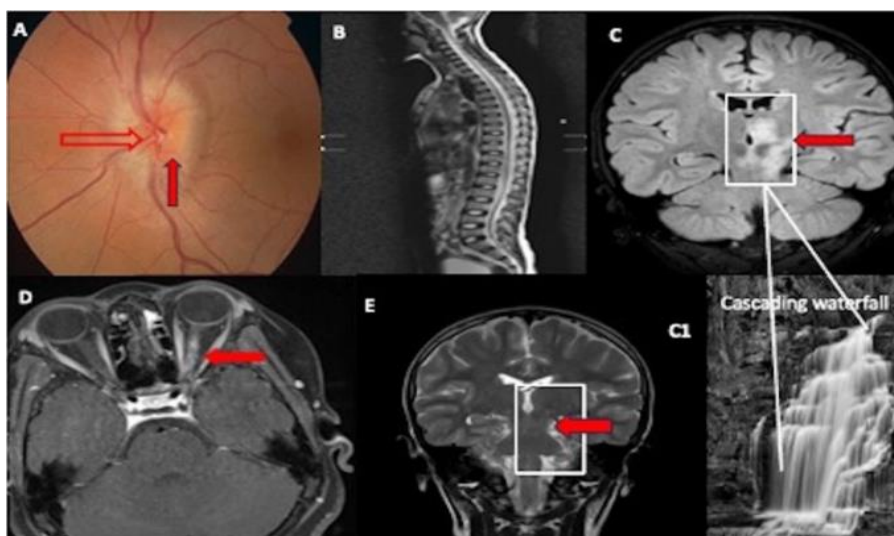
1A: Fundus findings in the Left eye: Open arrow: intense hyperaemia of the optic disc. Filled arrow: obliteration of the optic cup. 1B: normal MRI Whole spine. 1C and C1: the Cascade or the waterfall sign on the T1 Weighted Coronal FLAIR (Fluid attenuated inversion recovery) MRI Brain sequence. 1D: Enlargement and hyperintensity of the left optic nerve are observed in fat suppression STIR (Short-tau inversion recovery) MRI sequence (red arrow), suggesting a left ON. 1E: T2-weighted Coronal MRI Brain sequence showing complete resolution of the parenchymal lesion (Cascade sign) at 1 year of treatment duration.
